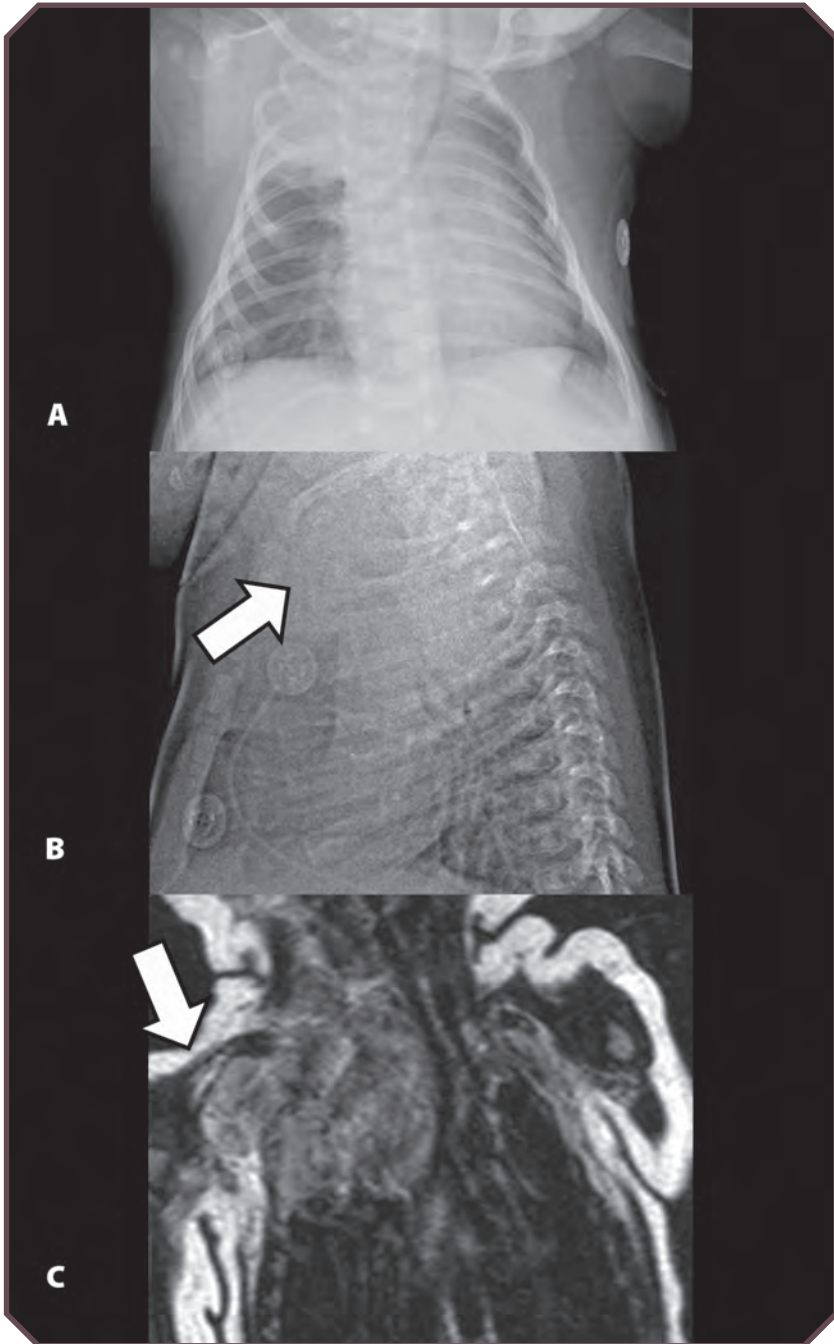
Neuroblastoma in an 18-month-old boy with opsomyoclonus. A. Frontal and B. lateral chest radiographs demonstrate a right apical chest mass. Note anterior displacement of the trachea on the lateral view (arrow). C. Coronal T2-weighted magnetic resonance image confirms a heterogeneous, hyperintense mass (arrow).
